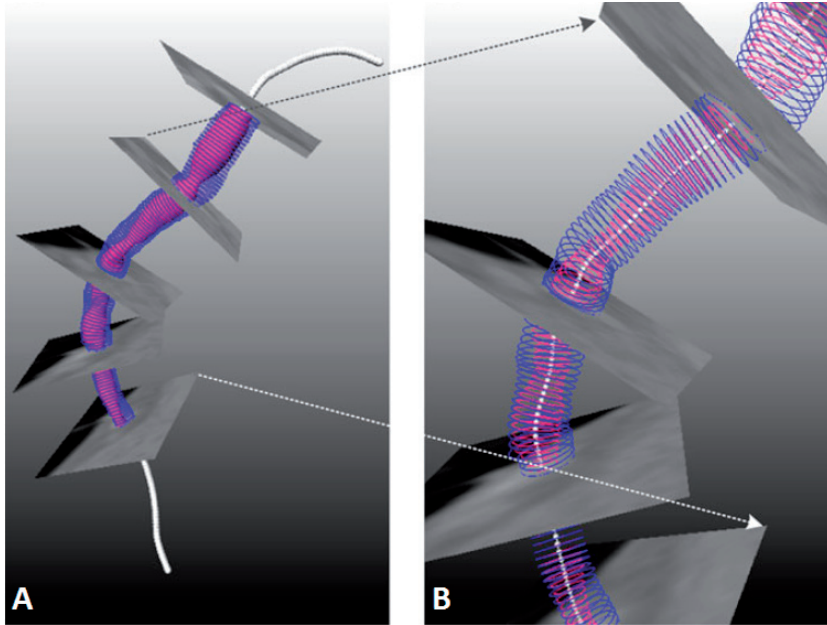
Example of fusion of CTA and IVUS data. The 3D centerline from the coronary artery is reconstructed from the CTA data. The square planes show the CTA data perpendicular to the centerline. The pink contours represent the lumen contours segmented from IVUS data, the blue contours the outer wall. These contours were aligned perpendicular to 3D centerline. A: Full view of the reconstructed centerline of coronary artery. B: Close up of the middle segment of panel A. (Adjusted from Van der Giessen et al.⁸⁶)
